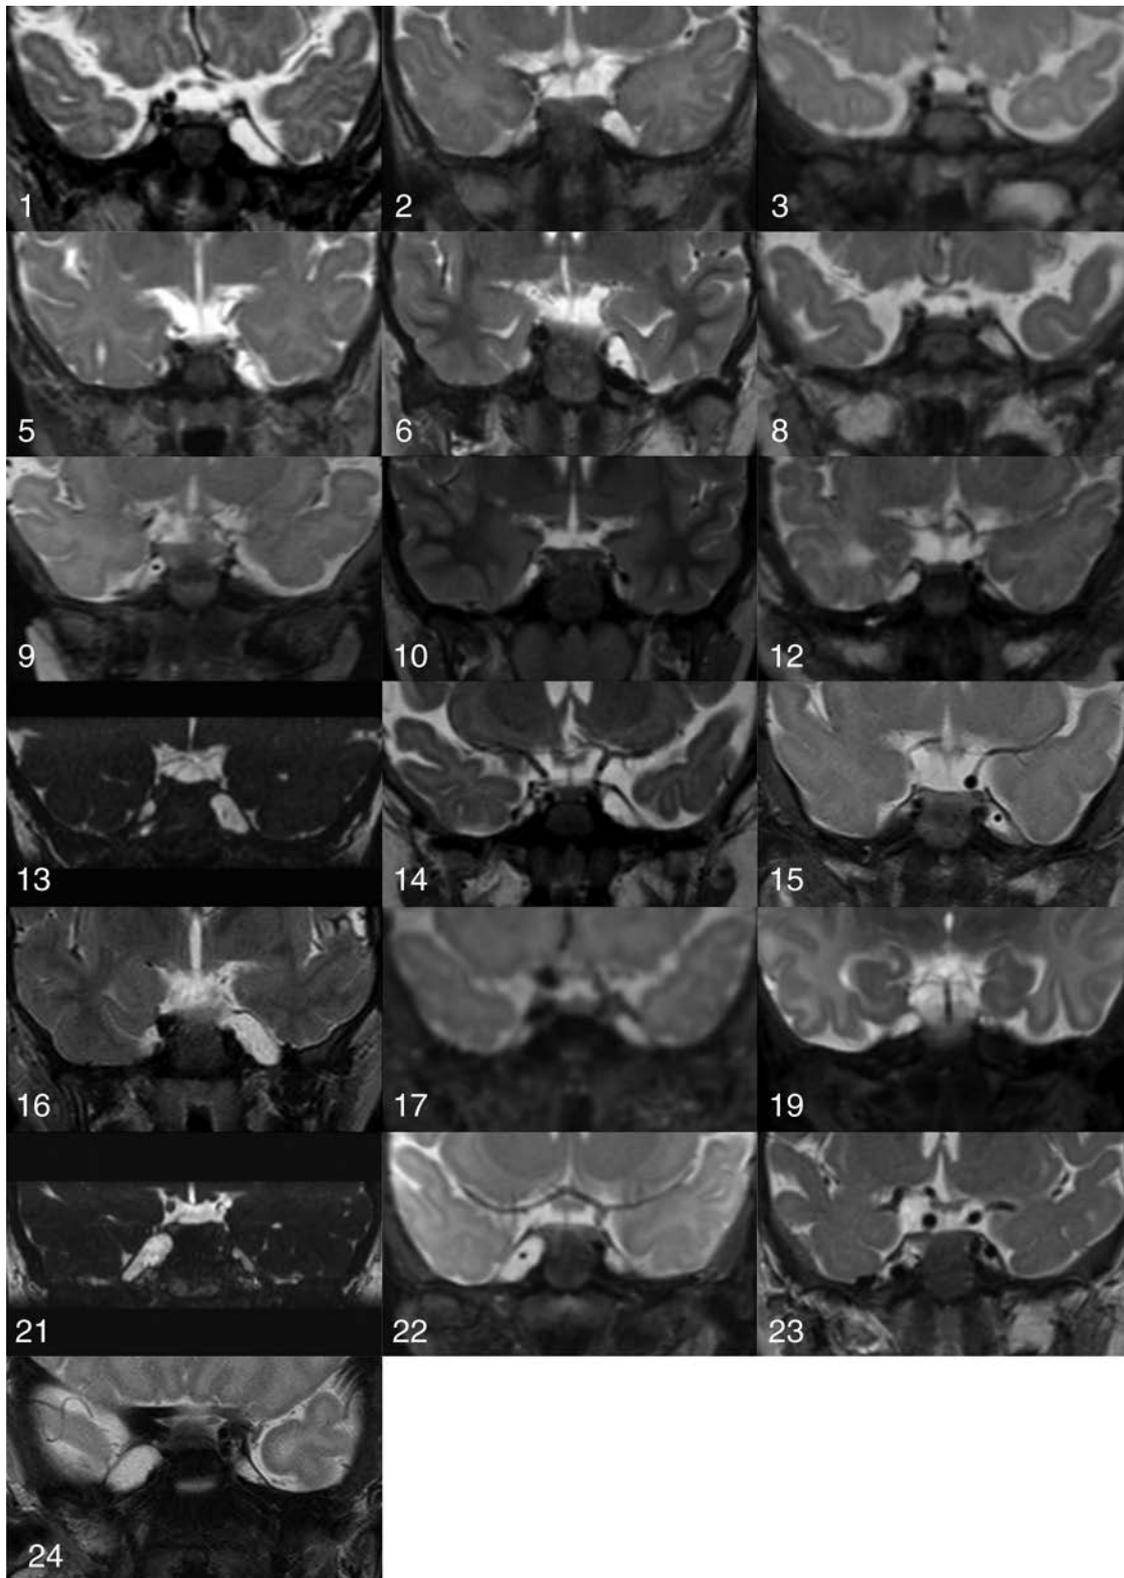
Coronal fluid-sensitive MR images through the bilateral Meckel caves of all patients with asymmetric Meckel cave enlargement. The vascular structure in the enlarged Meckel cave in patients 6, 9, 15, and 22 represents an ipsilateral aberrant ophthalmic artery arising from the basilar artery. The vascular structure in the enlarged right Meckel cave in patient 23 (Fig 2) represents an ectatic persistent trigeminal artery supplying the distal internal carotid artery.
